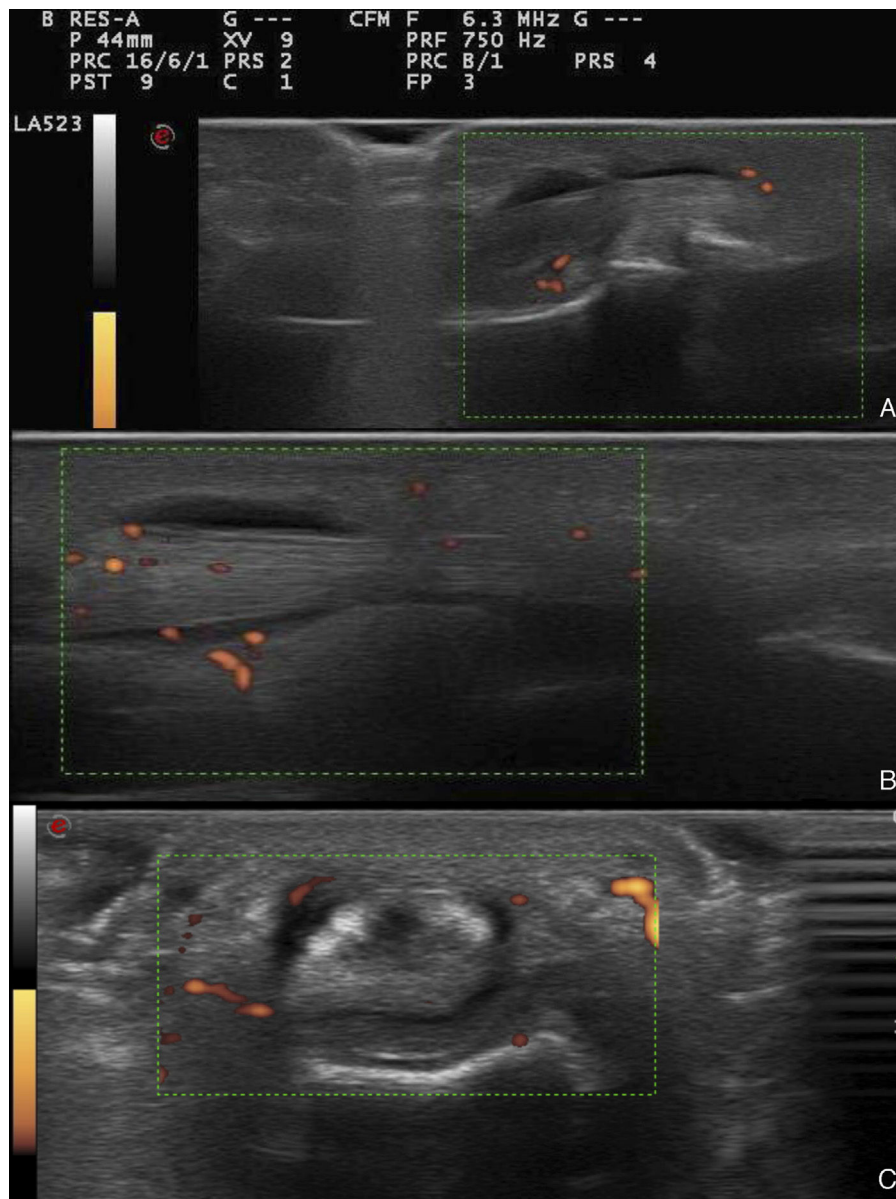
Ultrasound images of the 4th finger of the patient's right hand. (A) Long-axis view of middle-distal phalanges, with grade 1 power Doppler signal. (B) Long-axis view of proximal phalanx-metacarpus, with grade 2 power Doppler signal. (C) Cross-sectional view of proximal phalanx-metacarpus, with grade 2 power Doppler signal.
